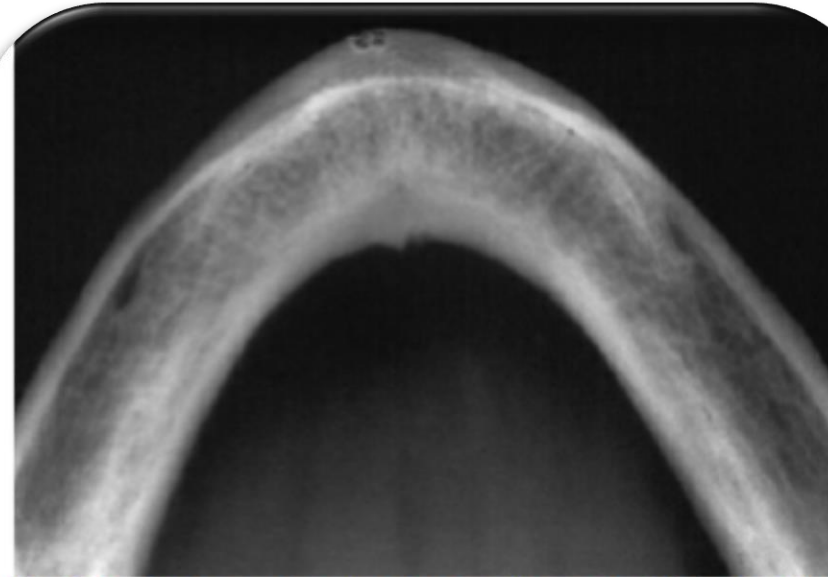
Cross-sectional occlusal radiograph of the edentulous mandible. Note that only the widest buccolingual contours of the mandible are visualized; these are usually located inferior to the desired implant site. This could result in an overestimation of the amount of buccolingual bone available.
